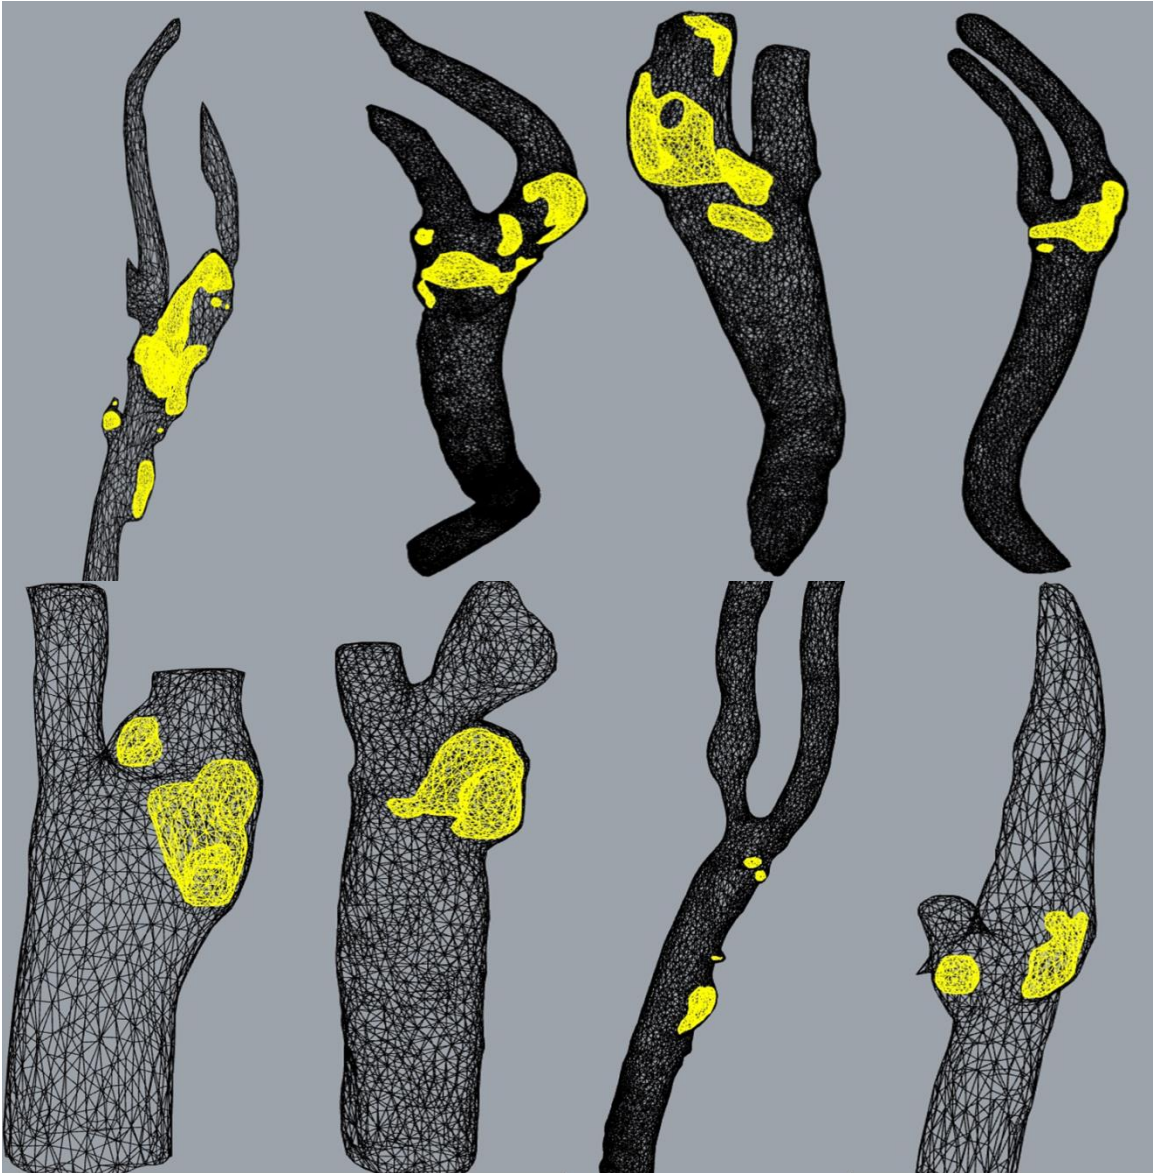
Overall coronal mesh view of the segmented arteries and calcification from CT images belonging to 12 cases out of 20 cases. Yellow objects express calcifications.
